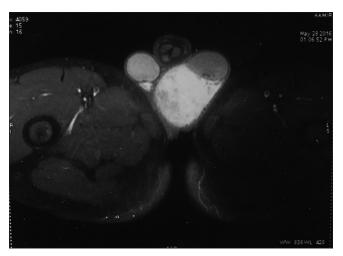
Preoperative magnetic resonance imaging image showing heterogeneously enhancing mass in the paratesticular region in axial view
